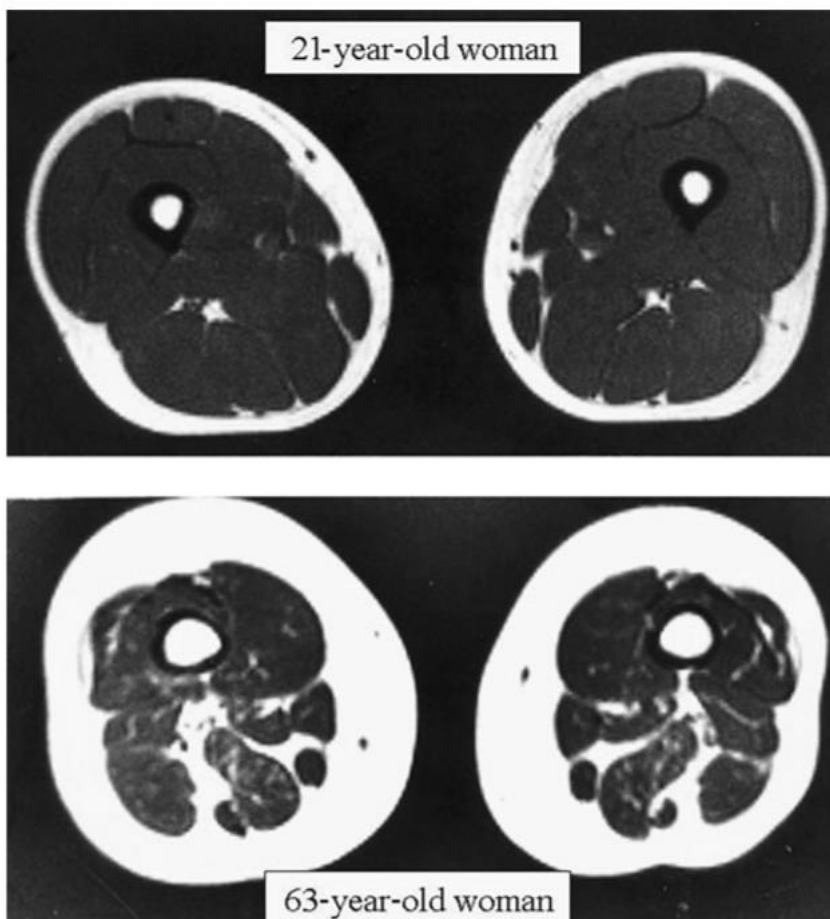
Cross-sectional CT images of the mid thighs of a younger and an older woman
